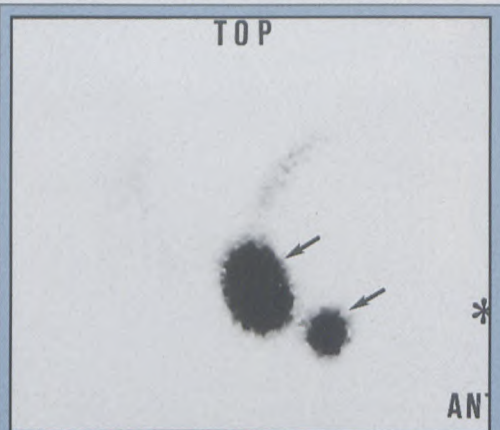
Right lateral view of the thyroid Tc O4 scintigram demonstrating the ectopic thyroid tissue in the sublingual region (arrows). The asterisk denotes the symphysis menti.
